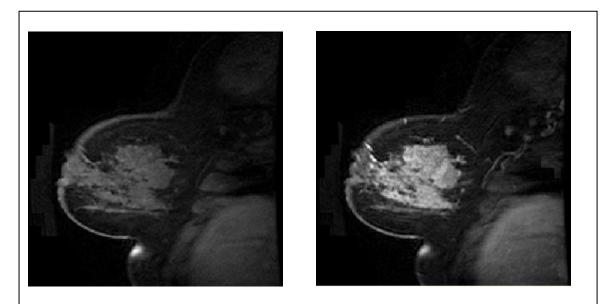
pre-contrast (left) and post contrast (right) at 2min post Gd injected MR images of breast, image on right shows enhanced lesion area. Images taken from data acquired by The University of Hull of patients undergoing neoadjuvent chemotherapy.
